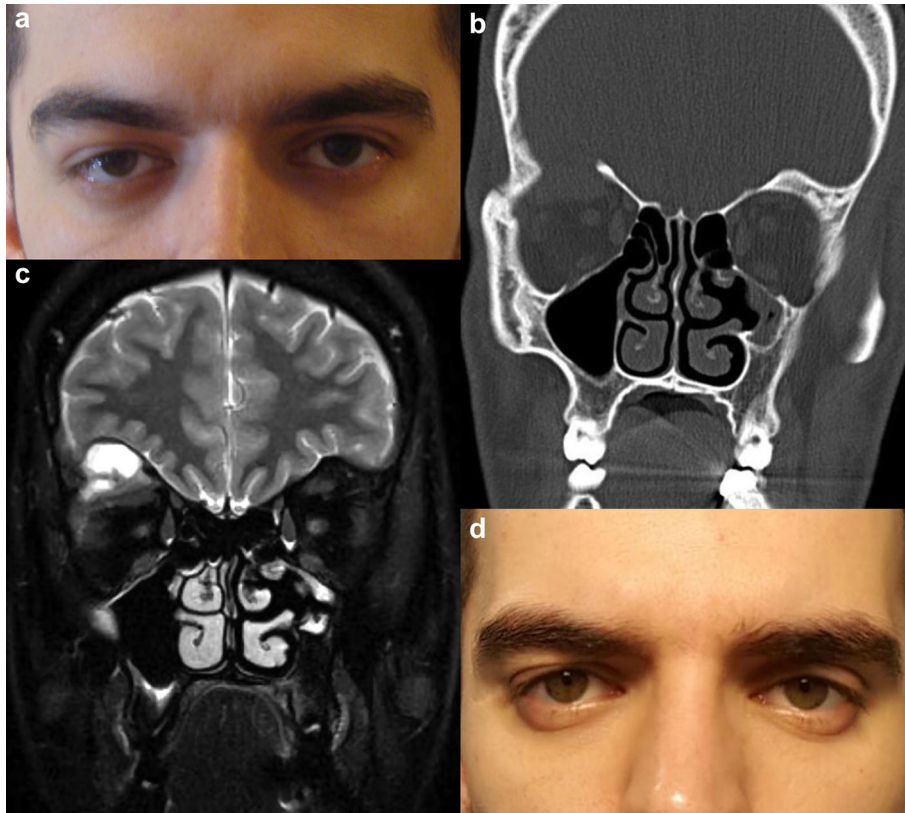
24-year-old man with eosinophilic granuloma of the right orbit. (a) Facial photograph shows right upper eyelid edema of 2 months duration. (b) Coronal orbital computed tomography shows an extraconal soft tissue mass measuring 20×15 mm in size, compressing the eyeball and destroying the right orbital roof. (c) Coronal magnetic resonance imaging shows upper orbital mass causing destruction of the orbital roof with dural thickening and contrast enhancement. (d) Facial photograph at 3 years follow-up status post orbitotomy, tumor excision, bone curettage, intralesional steroid injection, and systemic chemotherapy (vinblastin + prednisone) shows no residual disease.
